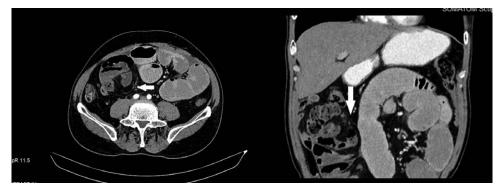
CT imaging dilated small bowels loops, encapsulated by a membrane (arrow) and located in the right quadrant of peritoneal cavity.
